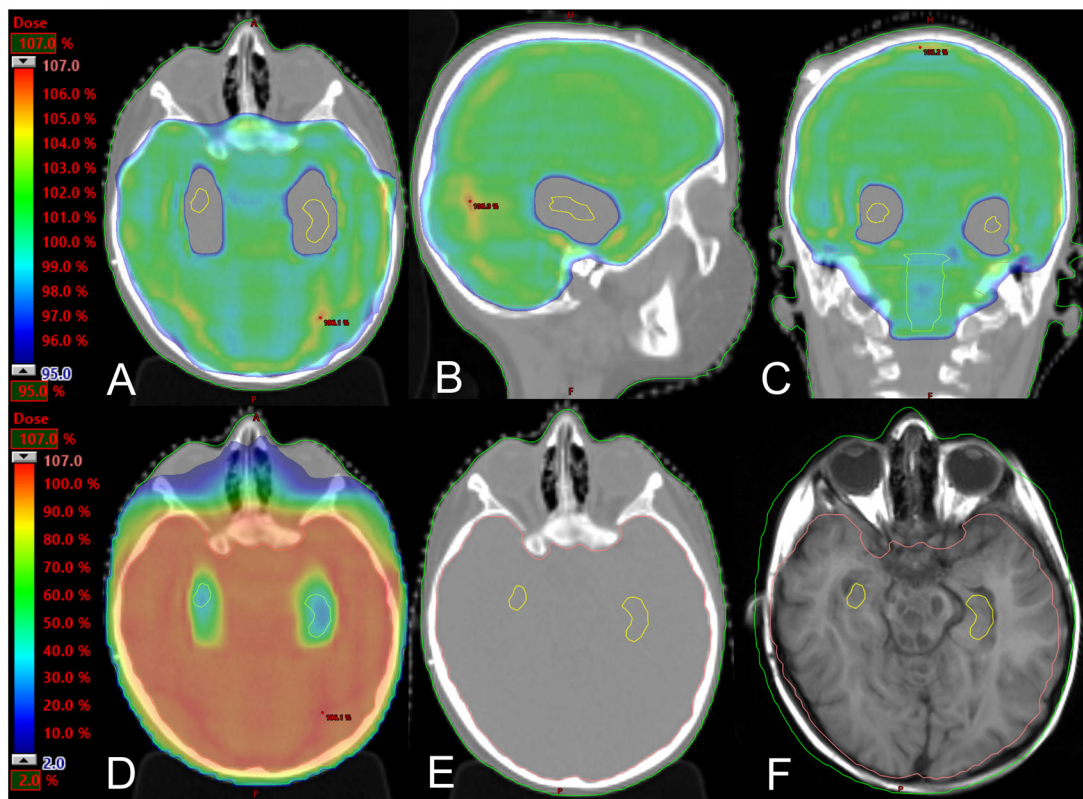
Absorbed dose in color-wash 95–107% for (a) transversal, (b) sagittal and (c) frontal view and absorbed dose in color-wash 2–107% for (d) transversal. A transversal slice of the (e) CT image and (f) T1-weighted MRI. All images show the contoured hippocampus (yellow contour). The hippocampal dose constraint was set to 9 Gy_{RBE} for the elective target.
